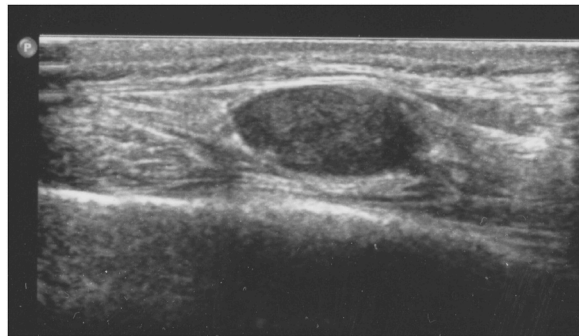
Ultrasonography showed the presence of a solid, hypoechoic, oval nodule, with clear contours, 1,8cm in diameter, with moderate vascularization and located within a muscular structure.
